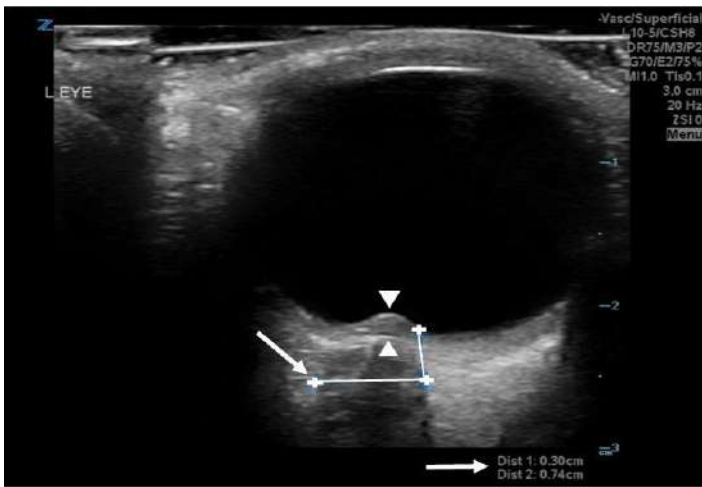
Left ocular ultrasound demonstrating optic disc elevation into the vitreous cavity (white arrow heads), as well as optic nerve sheath diameter measurements (white arrows)
